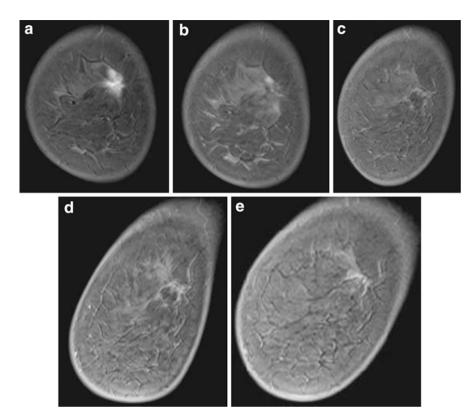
(a) Representative preoperative coronal T1-weighted magnetic resonance imaging (MRI) demonstrating a 15×10 mm-sized enhanced mass without surrounding intraductal extensions. (b) MRI performed 1 month after radiofrequency ablation (RFA). A small de novo enhanced lesion at the caudal end of the tumor may be observed, as compared to the preoperative enhanced tumor. (c) MRI performed 6 months after RFA. The enhanced lesion noted 1 month after RFA is absent, and slightly hypo-reflective lesions can be observed in the ablation zone. (d) MRI performed 1 year after RFA. The hypointense region in the ablation zone is reduced. A ring-shaped hyperintense region appears in the surrounding tissue outside the ablation zone. (e) Two years after RFA, normal mammary gland structures have appeared in the interior of the ablation zone
